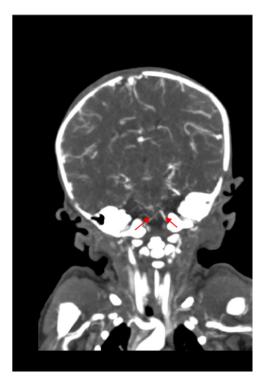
CTA head and neck, coronal view: no basilar artery is visualized in CT angiogram of head and neck suggesting long-segment basilar artery thrombosis (arrows point to V4 segments of vertebral arteries).
